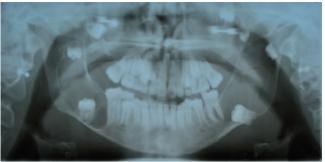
Panoramic radiograph demonstrates bilateral mandibular radiolucent lesions extending from first molars filling entire rami bilaterally. The second molars are displaced to inferior border, and the developing, third molar tooth buds are displaced superiorly. There are also radiolucent lesions in the right and left maxilla with displacement of multiple teeth
